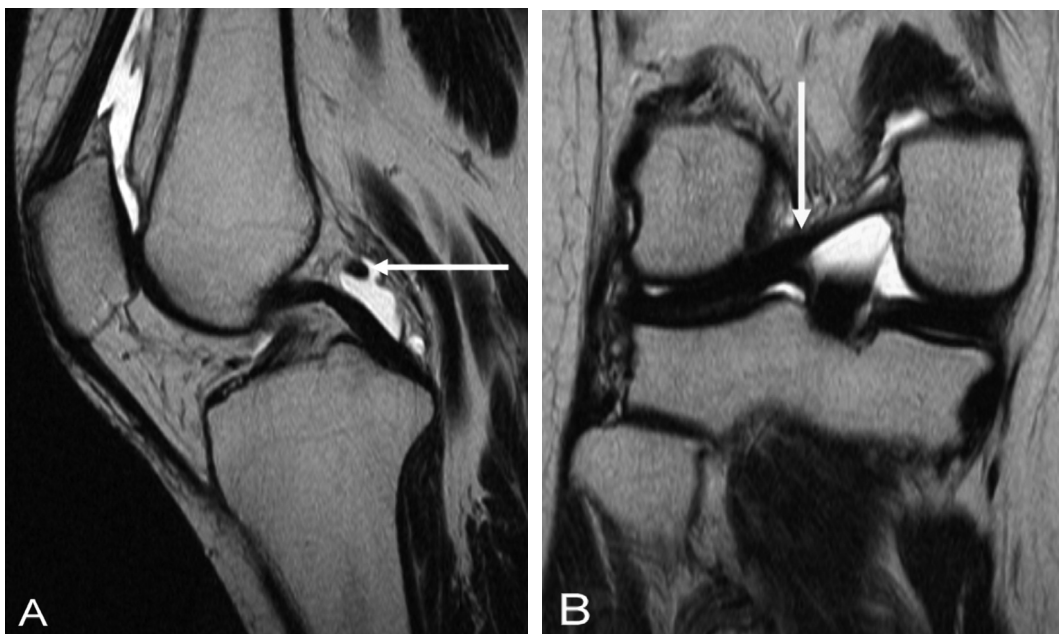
Meniscofemoral ligament of Wrisberg. (A) Sagittal T2-weighted turbo spin echo image. The meniscofemoral ligament of Wrisberg resembles a loose body surrounded by fluid (arrow). (B) The ligament has an unusually thick appearance in this case and is well visualized on the coronal T2-weighted image (arrow).
